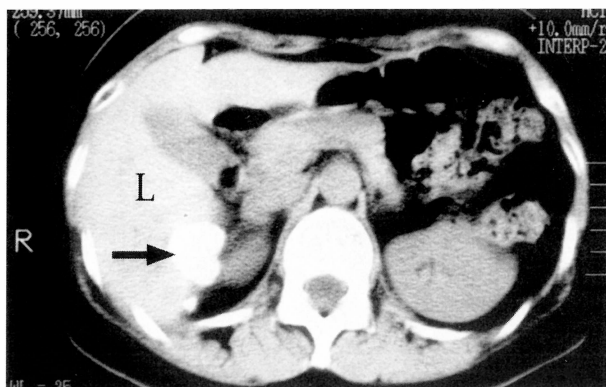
CT scan of the liver revealing a large calcified lesion.
